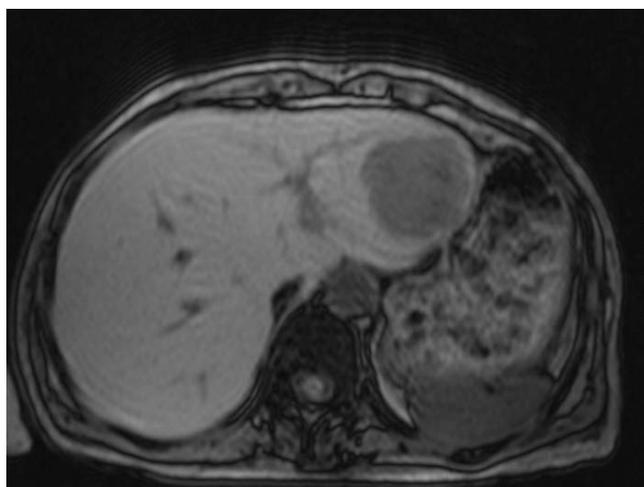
MRI: 5 cm metastasis in the left liver lobe (segment II).
